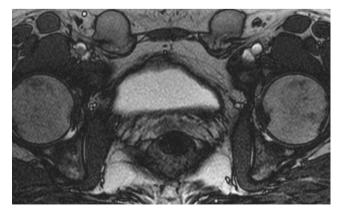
Pelvic magnetic resonance imaging showed the absence of the uterus and adnexa as well as a blind vagina.
